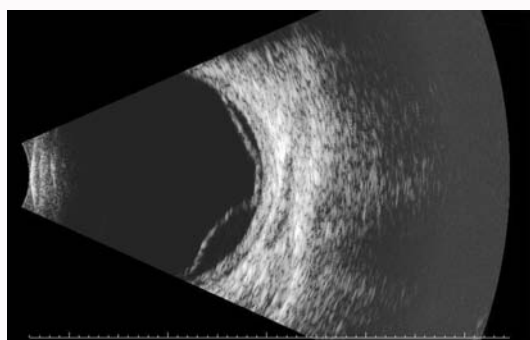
B-scan ultrasound shows clear vitreous with a retinal detachment.
